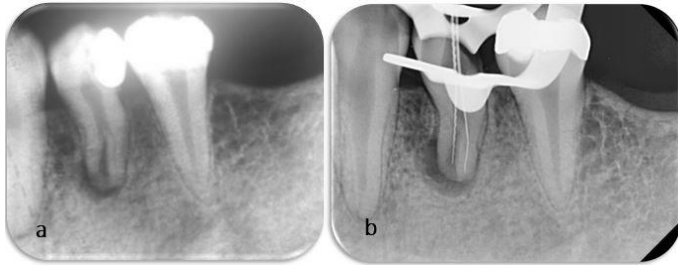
Periapical radiographs of tooth #21; A) Diagnostic periapical radiograph shows an unusual complex root canal anatomy; B) Working length determination radiograph shows two files in two canals
